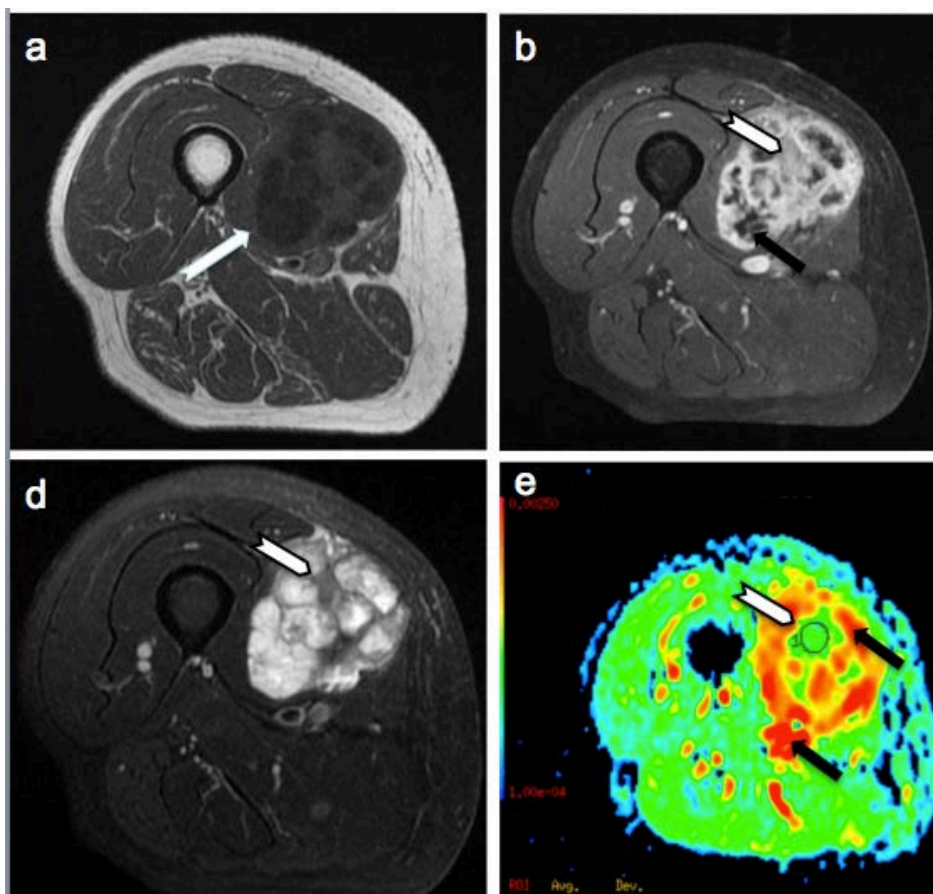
Schwannoma of the upper limb in a 78 year-old man. Axial T1 weighted (A), T2 weighted fat-saturated (B) and T1 weighted fat-saturated (C) MR images are shown. A well defined intra-muscular mass is seen at the vastus medialis (white arrows in A, B and C). This lesion has a heterogeneous predominantly hyperintense T2 signal, with cystic degeneration areas identified after gadolinium injection (black arrow in C). The ADC color map of this lesion at the corresponding anatomic region is shown in D. The minimal ADC zone is identified (white arrow) and estimated at  $1.83 \times 10^{-3} \text{ mm}^2/\text{s}$ . Note that the areas of cystic degeneration present high ADC values (black arrow).
